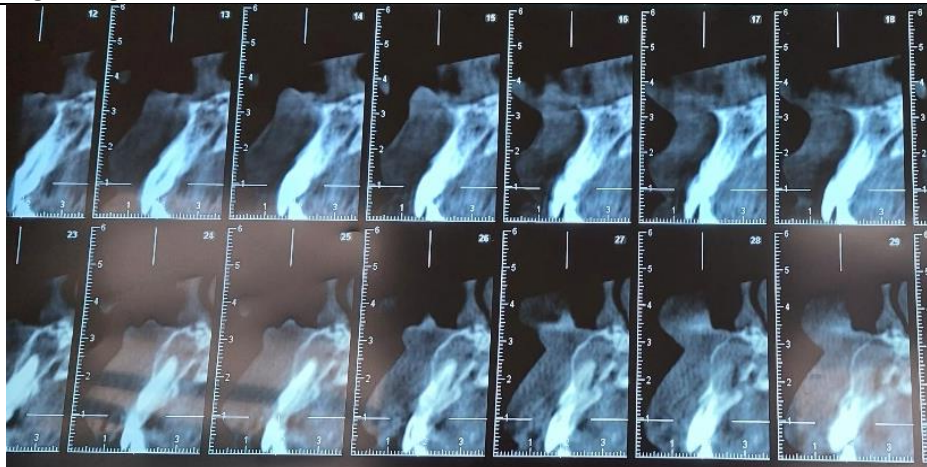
CBCT investigation : confirmation of initial diagnosis : periapical cyst with bone fenestration
